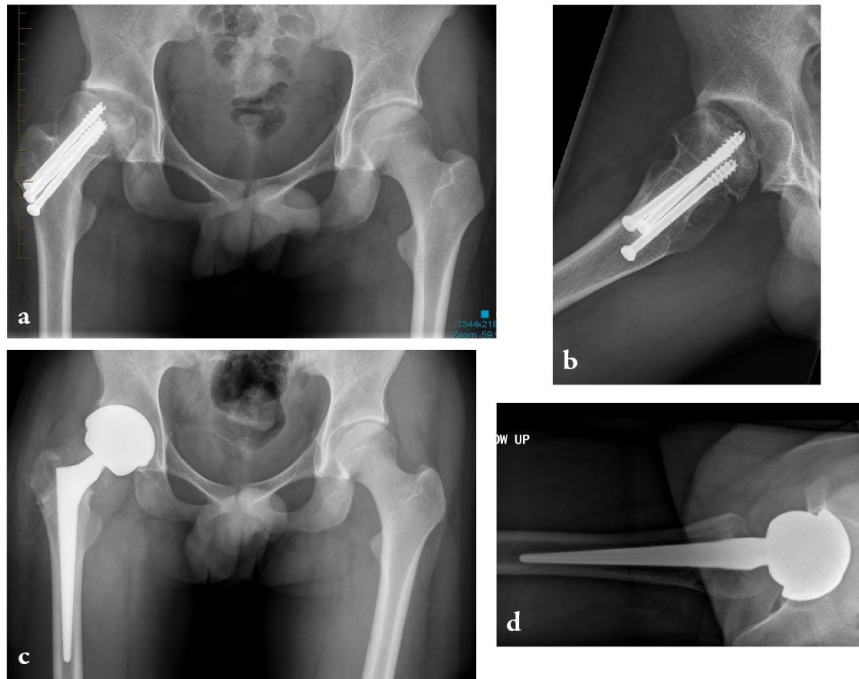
a) Anteroposterior pelvis radiograph of a 19-year-old man with right femoral head avascular necrosis following a slipped capital femoral epiphysis treated with cannulated screws. During preoperative templating, the acetabular and femoral component sizes were estimated to be small;
